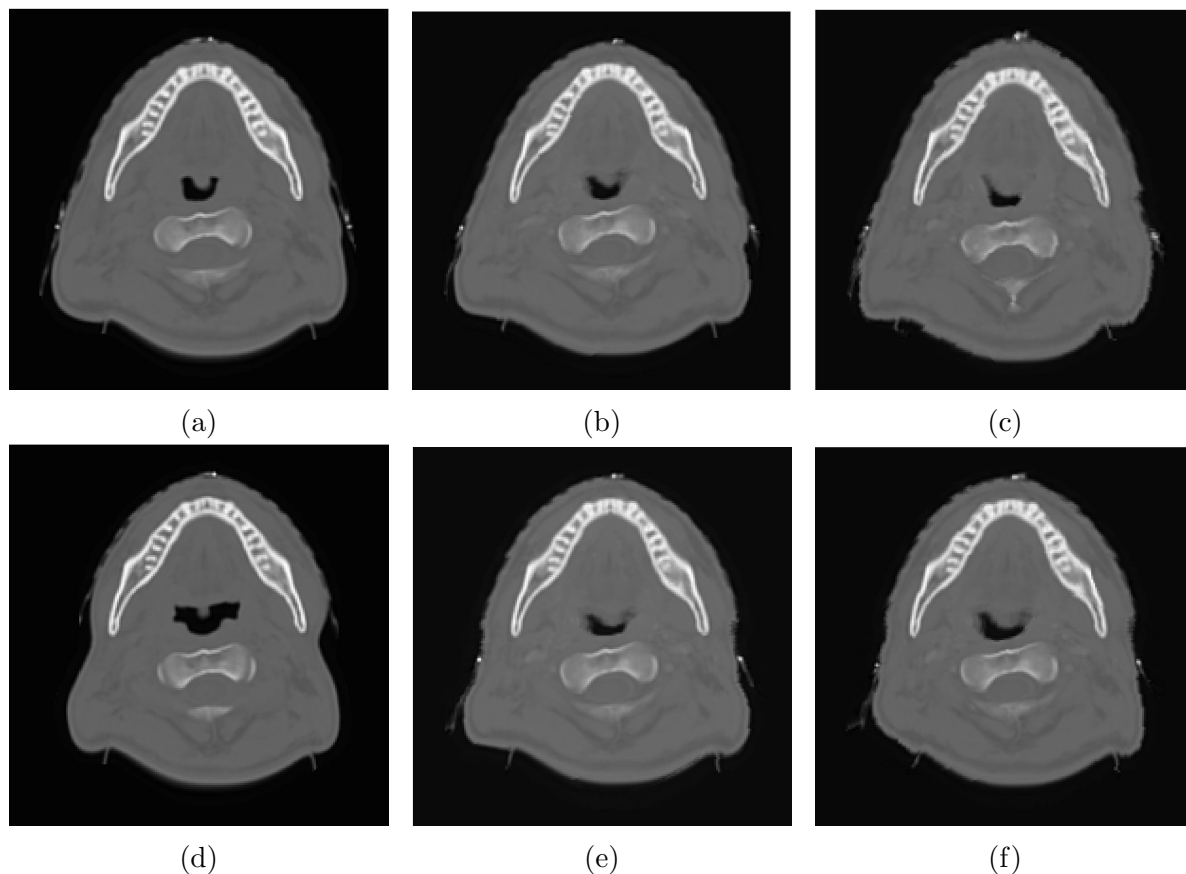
The exemplary patient’s slice images from the rCT_1 , rCT_6 and 2 predicted CT of the PM in the first week and the sixth week. (a) shows a slice image from the rCT_1 of the exemplary patient. (b)-(c) show slice images from 2 predicted CTs of the PM in the first week. (d) shows the same slice image from the rCT_6 of the exemplary patient. (e)-(f) show slice images from 2 predicted CTs of the PM in the sixth week.
